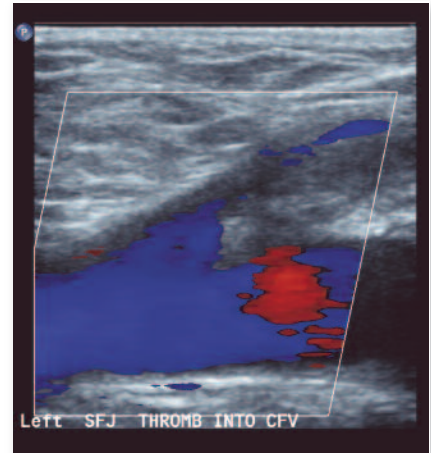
Duplex ultrasound demonstrating thrombosis of the greater saphenous vein extending to the junction with the common femoral vein with high risk of further extension/embolisation.
